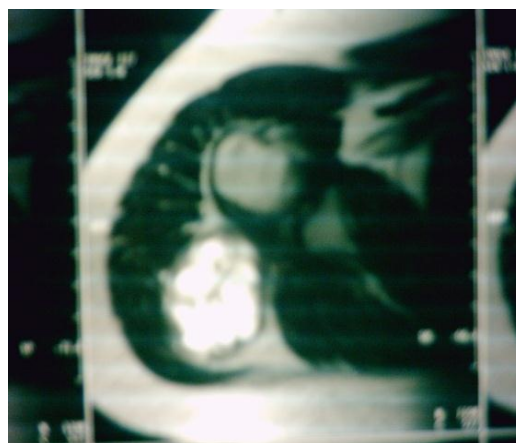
T2 cross section on MRI of the shoulder showing the hyper signal.
